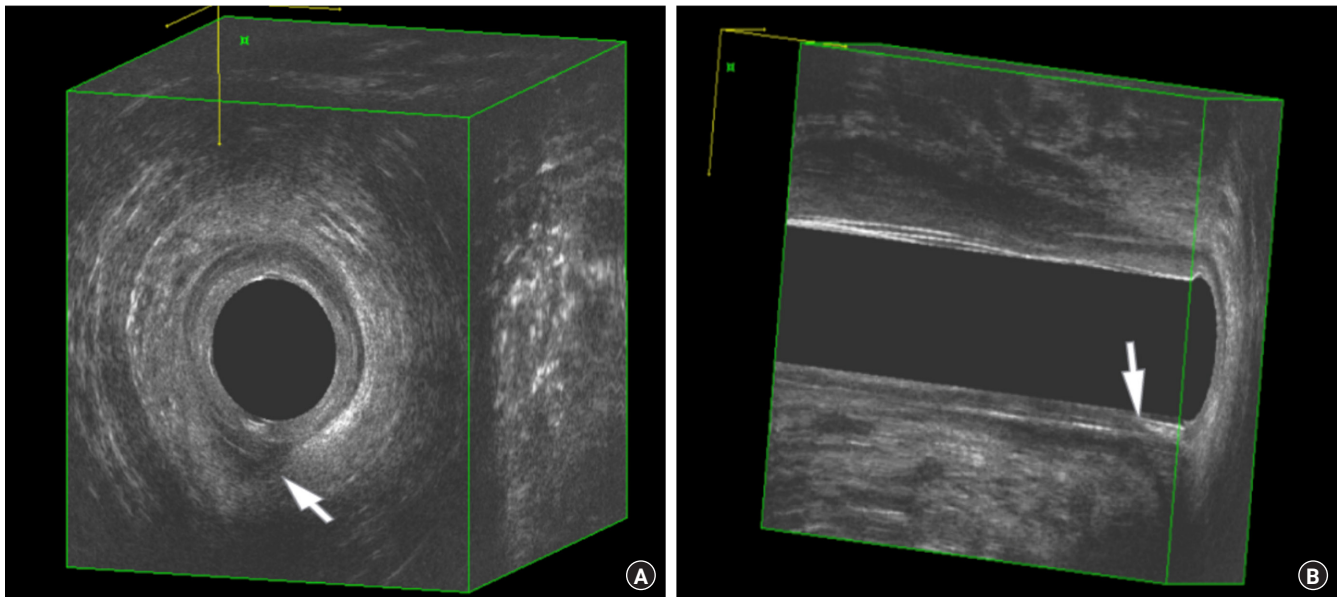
The 3-dimensional endoanal ultrasound images of a posterior submucosal fistula (arrows). (A) Axial plane. (B) Sagittal plane. Submucosal fistulas were categorized exclusively by the new classification.
